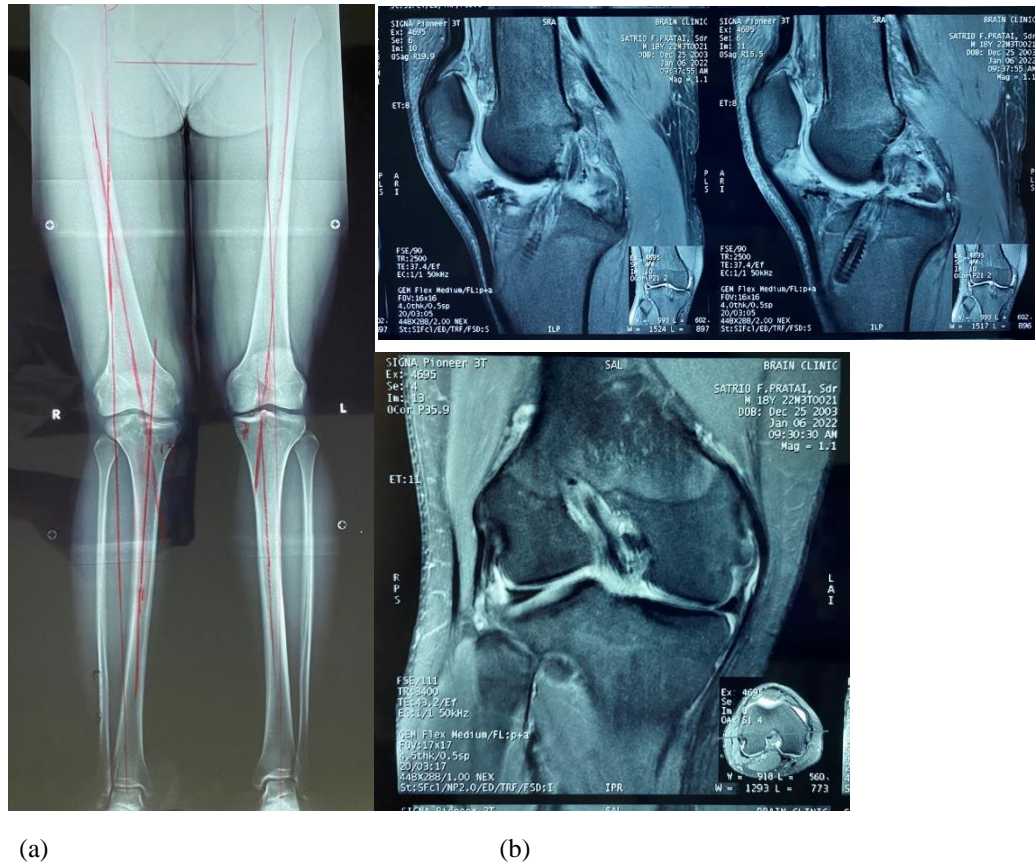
(a) Preoperative standing long leg radiographs; (b) MRI Sagittal view showing ACL graft rupture and also MRI coronal view showing intact PCL.
